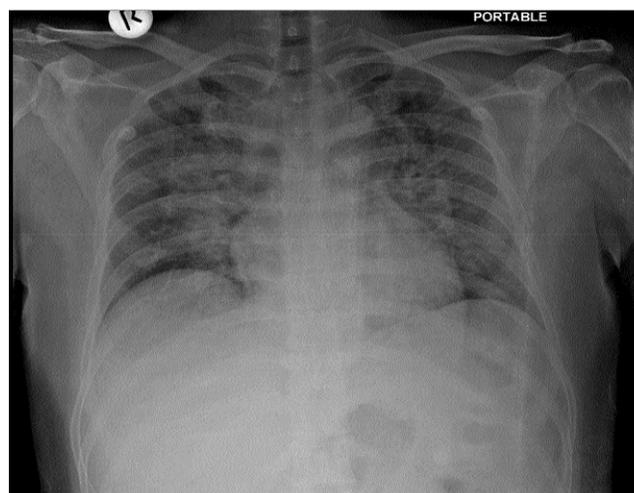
An Antero-posterior view chest radiograph. There is presence of dense air space consolidation with multiple confluent soft tissue nodular opacities in both lungs.
